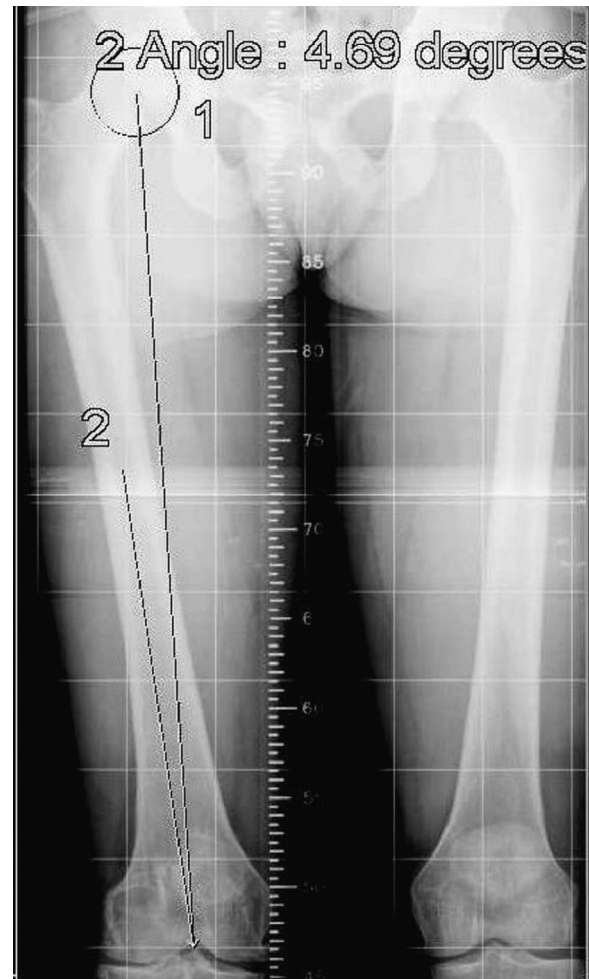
Magnification of the femur on a panoramic radiograph on the lower limbs showing the angle of the distal femoral resection determined by the intersection of the femoral mechanical axis (FMA) and the femoral anatomical axis (FAA).
